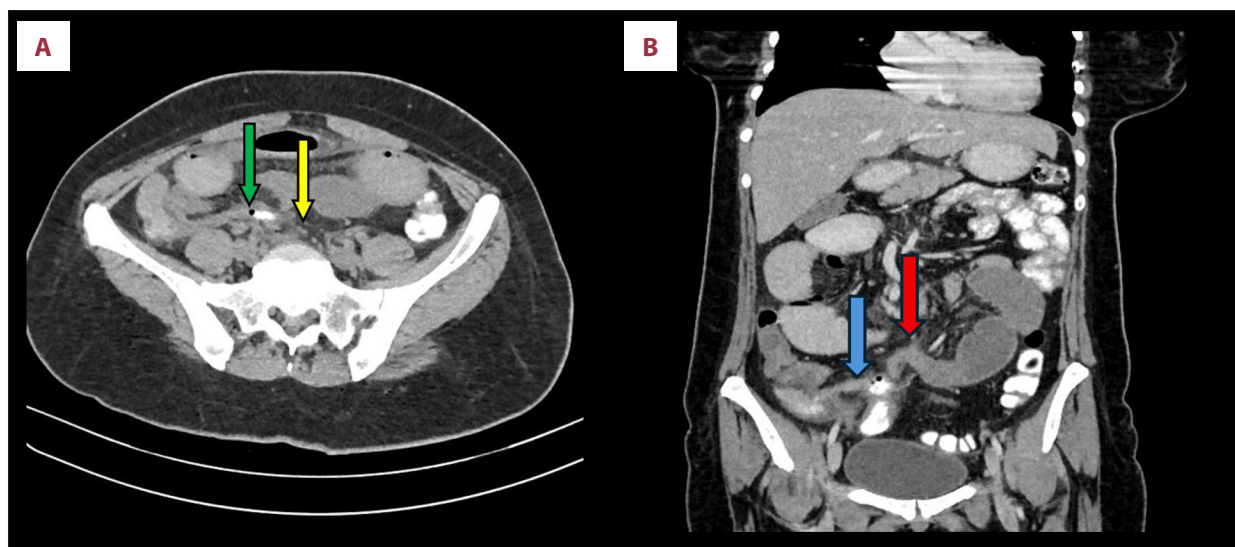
(A) Axial computed tomography image showing a fistulous communication between the appendix and sigmoid colon, with a thin streak of rectal contrast entering the appendiceal lumen (green arrow) and the adjacent sigmoid colon (yellow arrow). (B) Coronal computed tomography image showing an inflamed appendix containing an air bubble (blue arrow) in close proximity to the sigmoid colon, with dilated small bowel loops (red arrow).
